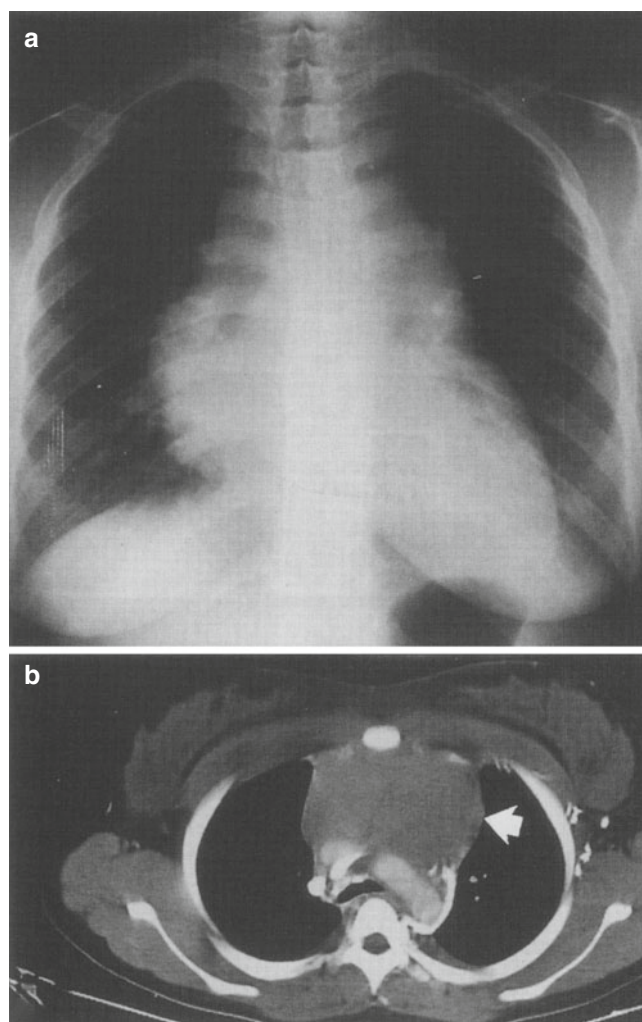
(a) Chest radiograph of a 12-year-old girl who presented with facial swelling and plethora. Chest radiograph demonstrated a significant anterior mediastinal mass. Echocardiogram revealed a pericardial effusion and the CT (b) revealed a homogeneous anterior mediastinal mass (arrow). Her white cell count was 5.1 with a normal differential count. Fluid aspirated from the pericardium, however, had a white cell count of 724,000 and cytology was diagnostic of lymphoblastic leukemia
